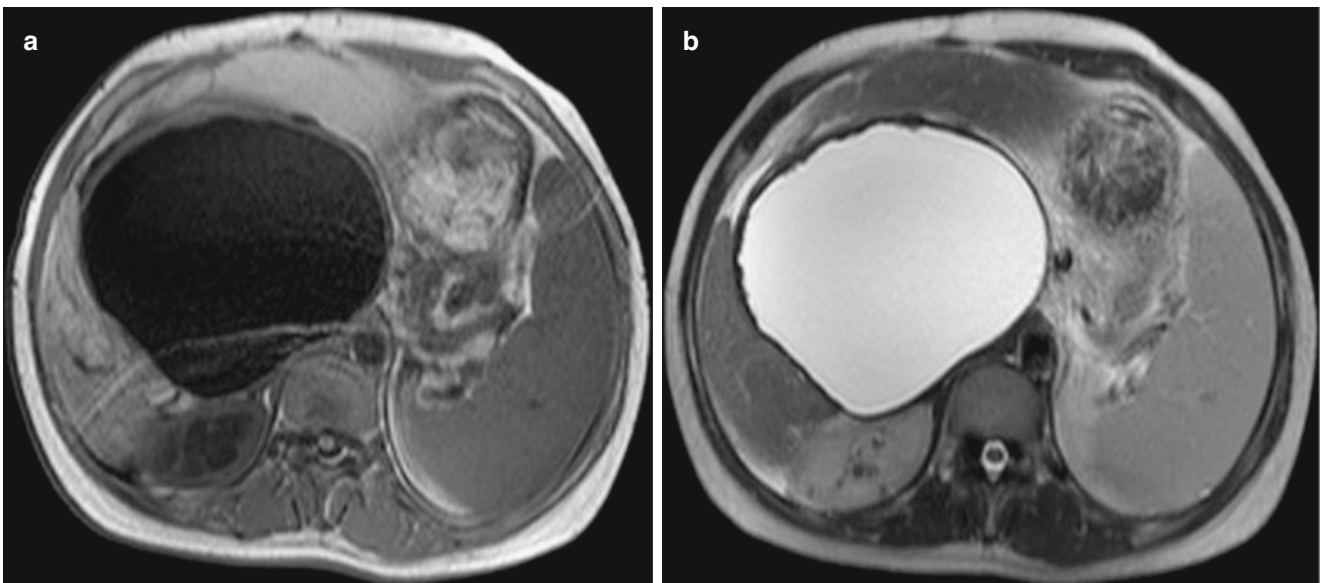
Hepatic cystic hydatidosis (singular type). (a, b) MR imaging demonstrates round-like lesion in the right liver lobe, with well-defined boundary as well as smooth and sharp margin. By T1WI, it is at low signal; by T2WI, high signal
